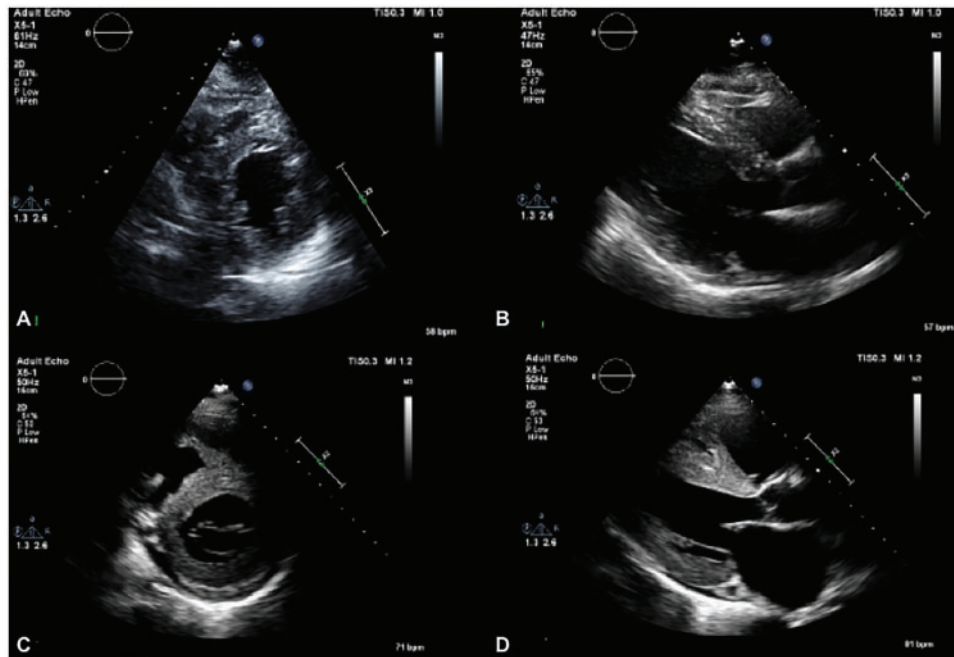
Transthoracic echocardiography of brother and sister pair with evidence of concentric left ventricular hypertrophy. (A) Parasternal short axis and (B) parasternal long axis views of the heterozygous transthyretin valine-to-isoleucine brother with left ventricular ejection fraction <20% and global hypokinesis with severe restrictive LV diastolic function. (C) Parasternal short axis and (D) parasternal long axis view of the homozygous transthyretin valine-to-isoleucine sister; with preserved left ventricular ejection fraction 65–70%.
